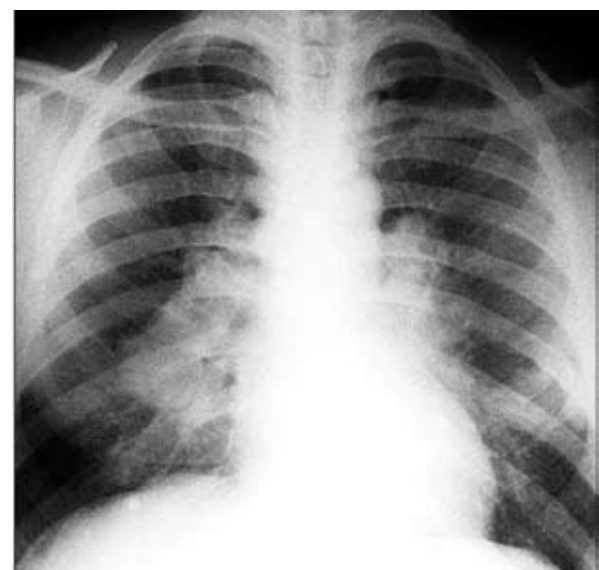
Chest radiography showed bilateral hilar lymphadenopathy.
